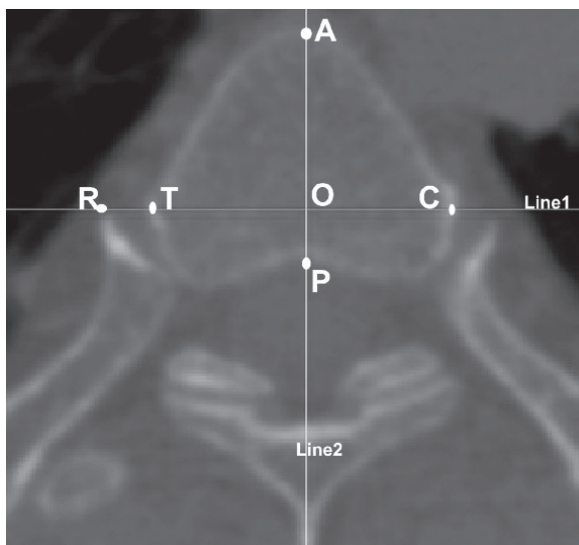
The distance between the anterior border of the rib head and the posterior margin of the vertebral body (ARHPVB), the distance between the anterior border of the rib head ("R") and the anterior margin of the vertebral body (ARHAVB), and transverse dimension (TD) (transverse CT): "Line 1" connects the most anterior aspect of the rib heads; "Line 2" is the line through the mid-sagittal plane of the vertebral body; "O" is the intersection between "Line 1" and "Line 2"; "A" is the point at which line two intersects on the anterior margin of the vertebral body; "P" is the point that line two intersects the posterior margin of the vertebral body; "OA" is the ARHAVB; "OP" is ARHPVB; and "TC" is TD.
